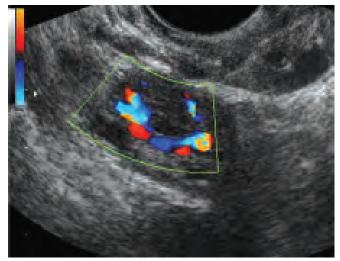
Transvaginal color Doppler scan of the corpus luteum, visualized as a ring of angiogenesis within the ovary
